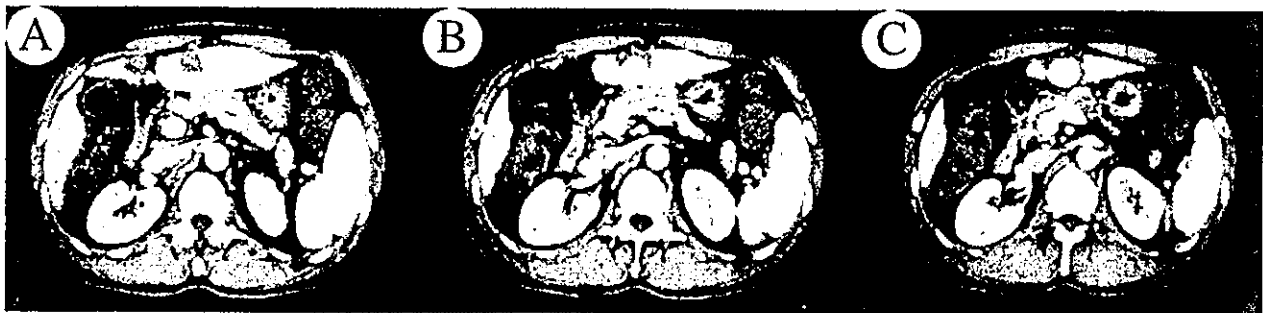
Contrast-enhanced CT of the tumors after treatment. The low density area around the lipiodol deposit of HCC (S3 region) was observed, indicating the safety margin area was obtained by laparoscopic PEI-RFA (A-C). The HCC on the S4 region was destroyed by treatment, and whole region of the tumor changed to the low density area (A).
